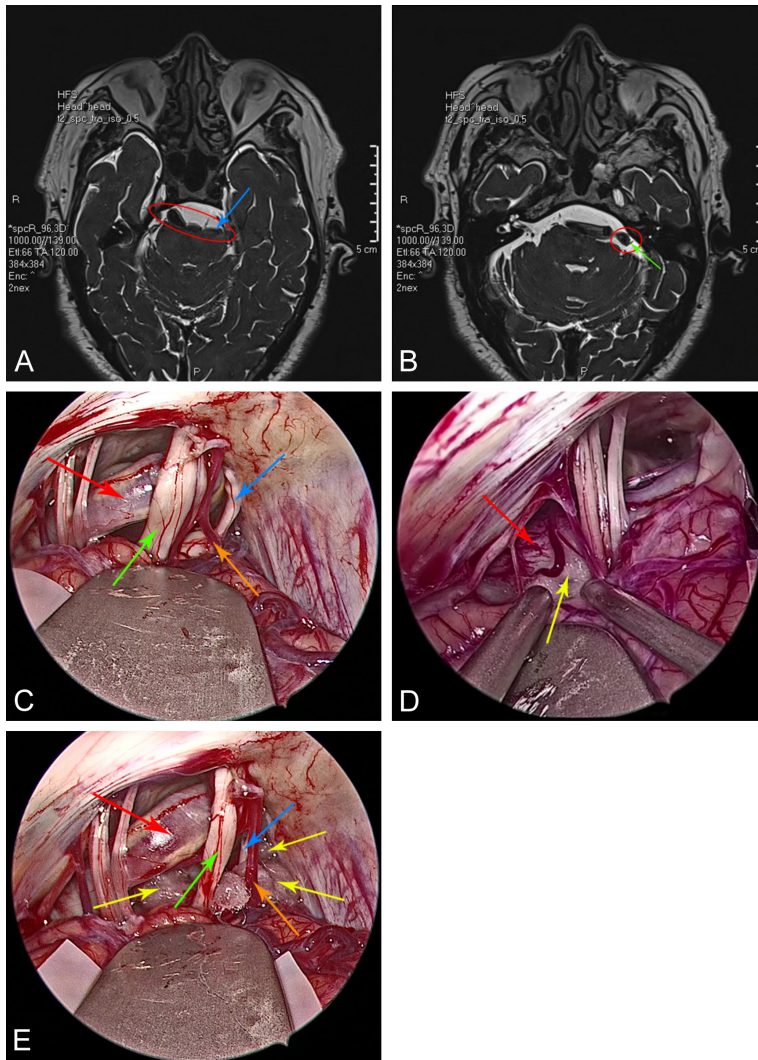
A, B. Preoperative head magnetic resonance imaging of the patient. The left vertebral artery compressed the trigeminal and facial nerve root. C. The offending vessels, left trigeminal and facial nerve, were clearly visible under the endoscopic view. D. A Teflon pad was inserted into the proximal end of the left vertebral artery. E. The Teflon pad was placed between the offending vessels and left trigeminal and facial nerve under the endoscopic view. Red circle indicates the lengthening and dilatation of the left vertebral artery, blue arrow indicates the left trigeminal nerve, green arrow indicates the left facial nerve, the red arrow indicates the left vertebral artery, the orange arrow indicates the small artery, and the yellow arrow indicates the Teflon pad.
